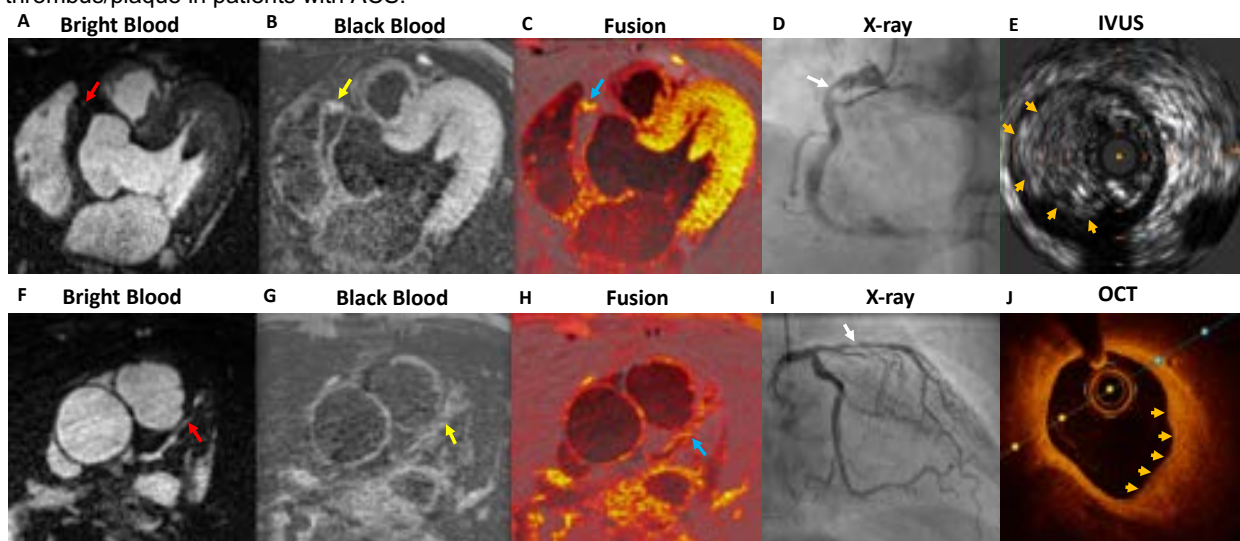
A- Bright blood coronary MR angiography showing a critical proximal RCA stenosis (red arrow). B- Acute intracoronary thrombus of the proximal RCA on black blood vessel wall images (yellow arrow). C- Fusion of the black blood vessel wall images with the black blood PSIR dataset for anatomical correlation (blue arrow). D- Critical proximal RCA stenosis on X-ray angiography (white arrow). E- Acute intracoronary thrombus on intravascular ultrasound (IVUS) (orange arrows). F- Bright blood coronary MR angiography showing severe proximal to mid LAD stenosis (red arrow). G- Diffuse atherosclerosis on black blood vessel wall images (yellow arrow). H- Fusion of the black blood vessel wall images with the PSIR dataset for anatomical correlation (blue arrow). I- Diffuse severe proximal to mid LAD stenosis on X-ray angiography (white arrow). J- Diffuse high signal fibrotic atherosclerosis on optical coherence tomography (OCT) (orange arrows).
